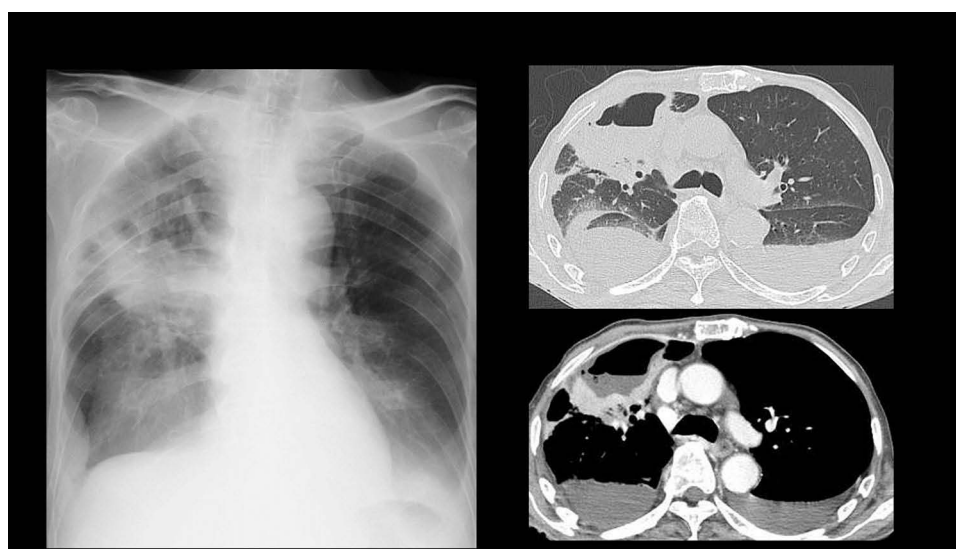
Chest X-ray and CT image when diagnosed with a lung abscess. Due to the patient's respiratory condition and the presence of *Pseudomonas aeruginosa* in his blood, he was diagnosed with a lung abscess caused by the bacterium.
